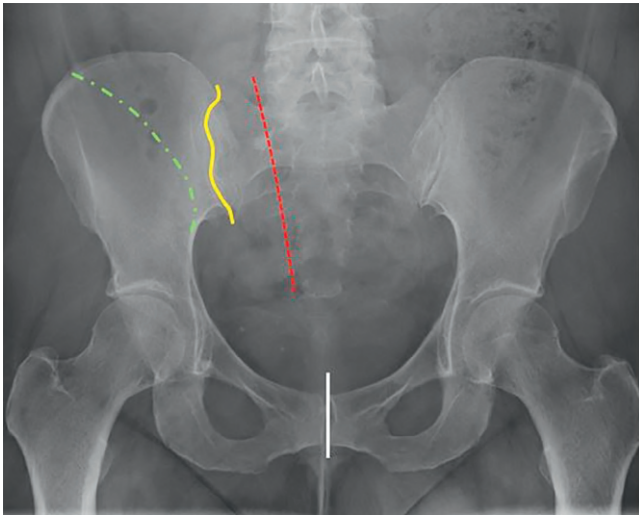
Anterior-posterior pelvis radiograph with levels of resection for a modified (green dashed line), standard (yellow line), and extended (red dashed line) hemipelvectomy. Anteriorly, the pelvis is transected at the pubic symphysis (white line).
